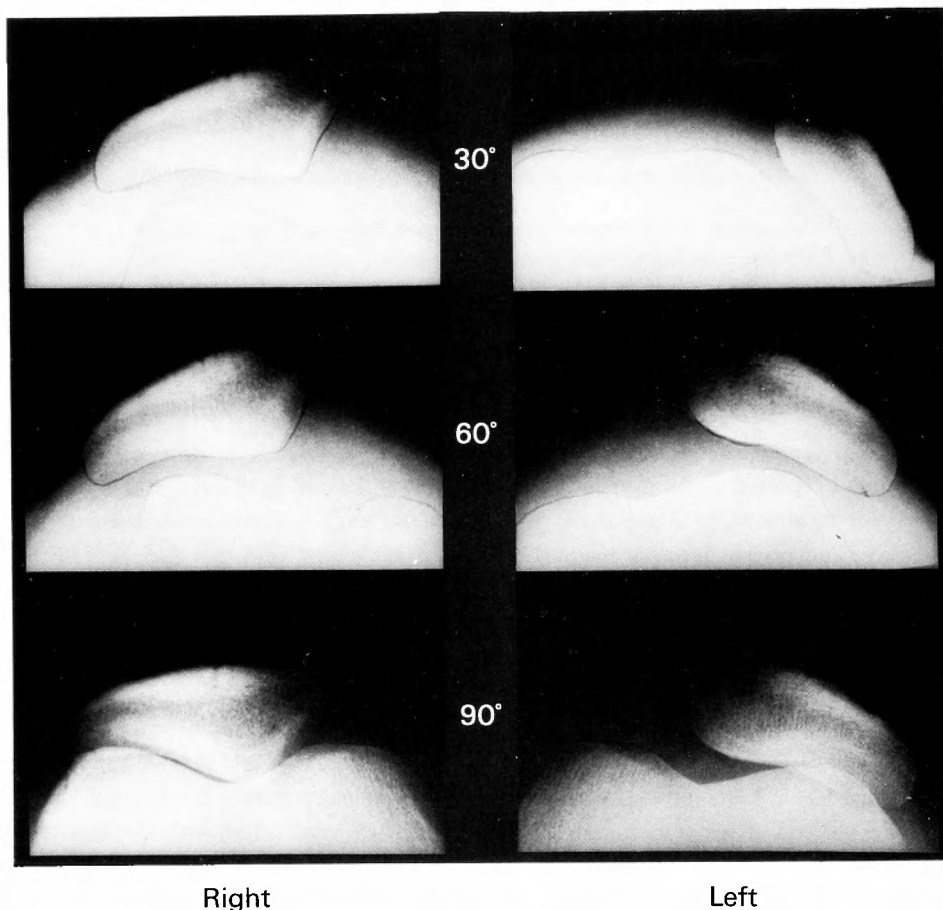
Roentgenogram in axial projection of the patella taken at first medical examination.
